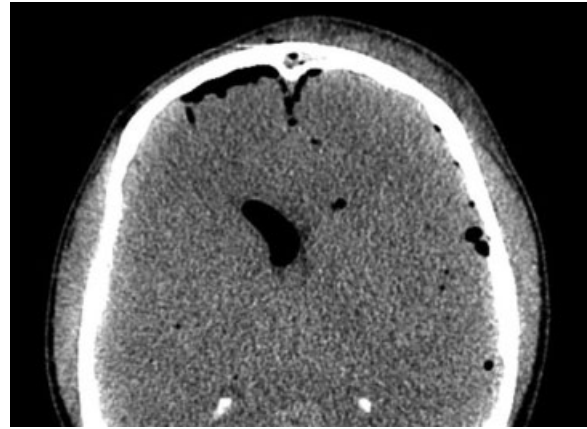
Plain CT of the brain, axial cuts, with gross edema and right frontal pneumoventricle and diffuse pneumo with right frontal pneumocephalus.
